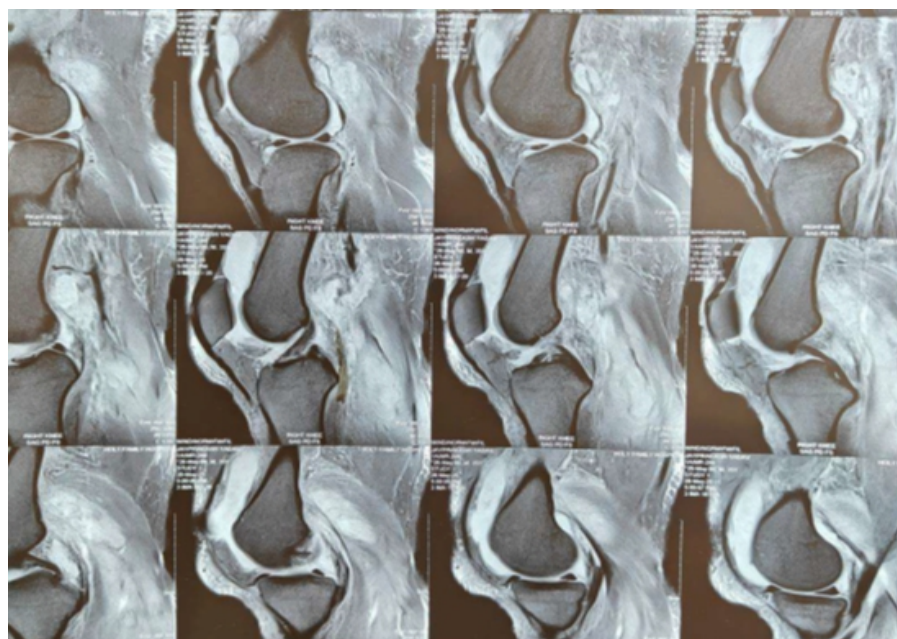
Magnetic resonance imaging (MRI) of the right knee (sagittal T2-weighted fat-suppressed image) showing moderate joint effusion with synovial enhancement and surrounding muscle edema suggestive of myositis. Usually, pyomyositis is diagnosed late, an immunocompetent individual presenting with only knee swelling, is likely to receive treatment for a few weeks before the infection spreads to other areas, one of the important points in this case was that the patient presented early to an orthopedic surgeon who ordered an MRI of the knee which also incidentally picked up the pus collections in the muscles making a diagnosis of pyomyositis.
